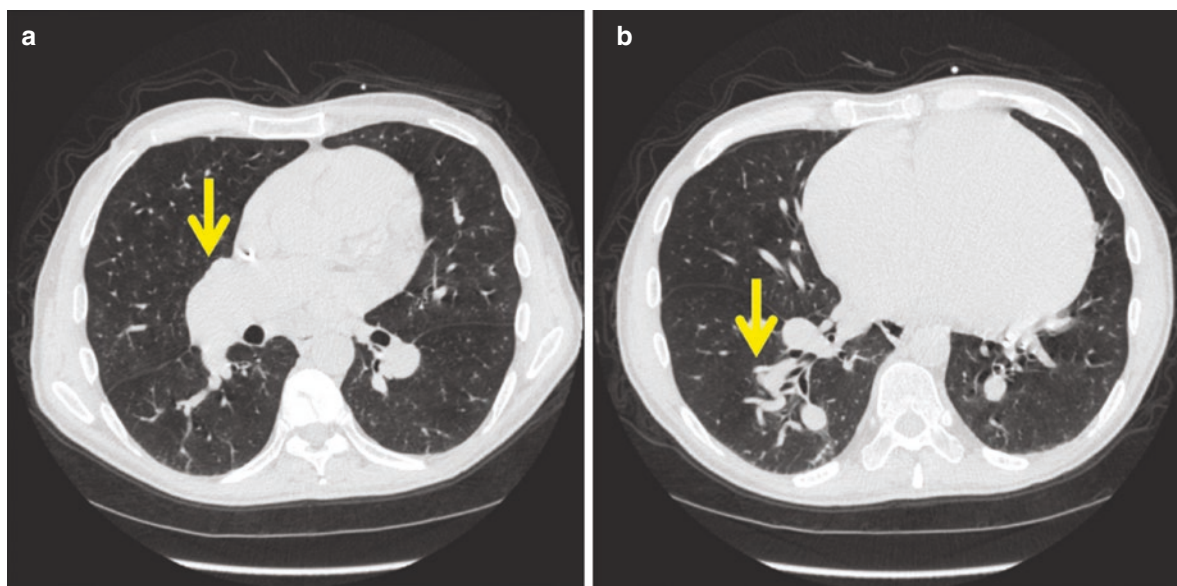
CT features of pulmonary arterial hypertension. (a) Severe enlargement of the main pulmonary arteries. (b) Thickening and tortuosity of the distal arteries (arrow), as well as right ventricular enlargement. Notice the absence of significant underlying parenchymal lung disease
